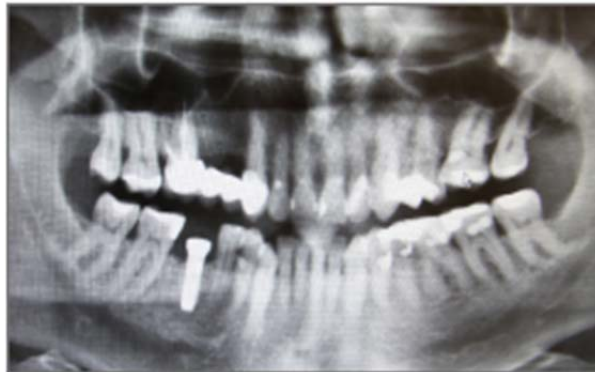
Panoramic radiograph two months after implant insertion.
